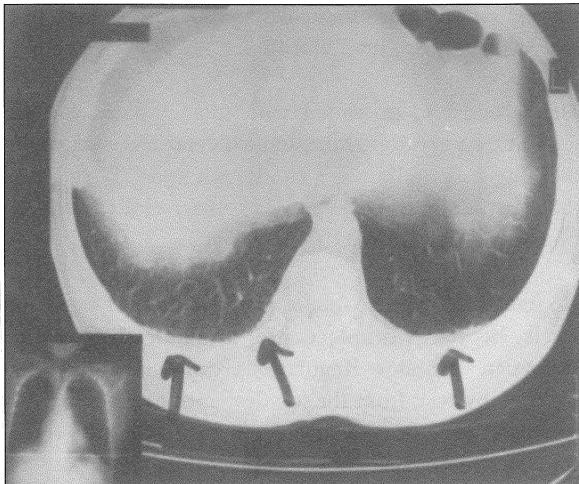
HRCT of the thorax of patient 1 showing bilateral pleural thickening and calcifications, mainly in the mid and lower zones posteriorly.
